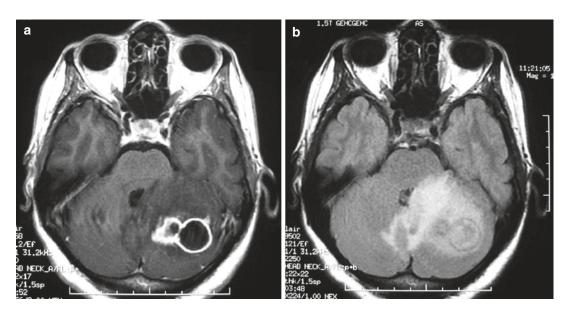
TB cerebellar abscess in the *left* side with surrounded edema. Axial T1-weighted MRI following gadolinium injection (a) and on FLAIR sequence (b)
